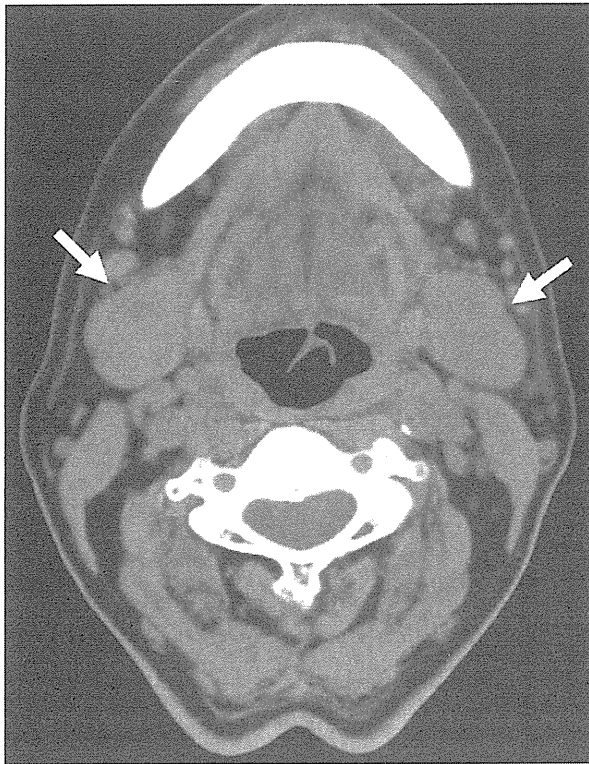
IgG4-related sialadenitis. On T1 axial computed tomography, there is swelling of the submandibular salivary glands (arrows).
